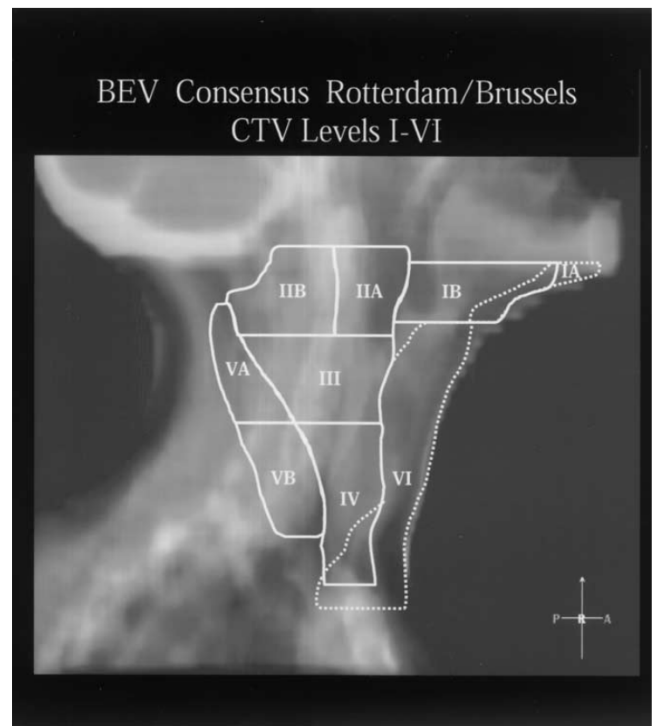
Lateral view of digitally reconstructed radiograph of CTV of Levels I–VI.
